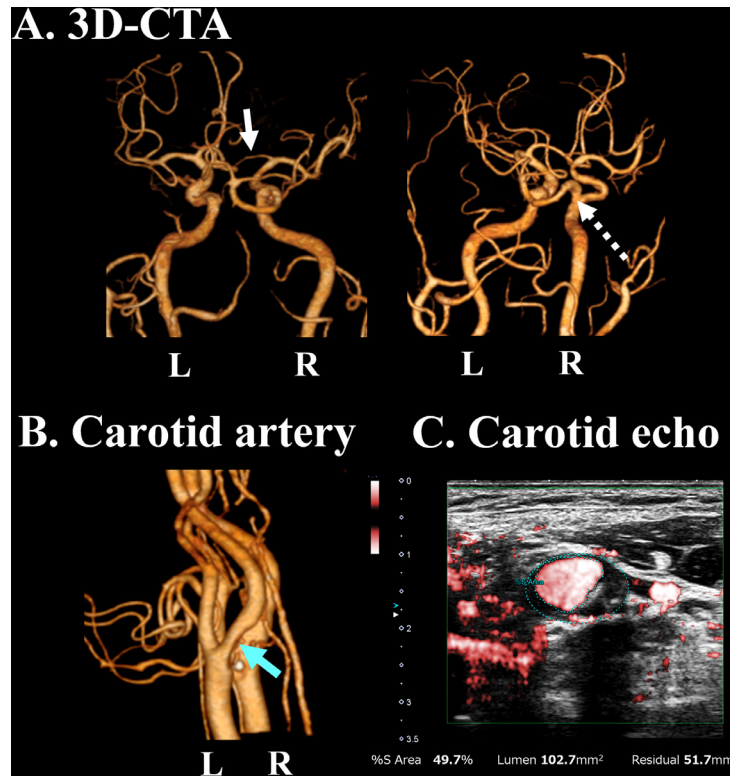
(A) On three-dimensional computed tomography angiography, the A1 segment of the right anterior cerebral artery was hypoplastic (white arrow). The left vertebral artery was identified but the basilar artery was aplastic. A persistent primitive trigeminal artery originating from the cavernous portion of the right internal carotid artery supplied blood flow to the distal basilar artery (dotted white arrow). (B) Moderate stenosis was identified in the left cervical internal carotid artery just distal to the bifurcation (blue arrow). (C) Carotid ultrasonography showed 49.7% stenosis of the left cervical internal carotid artery.
